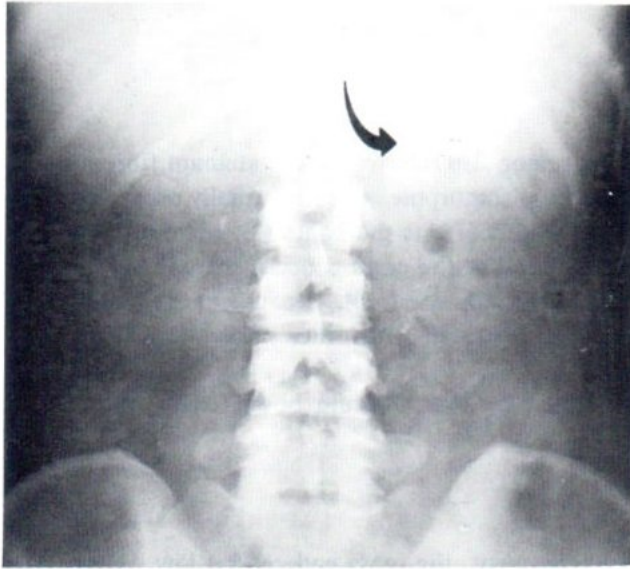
Plain film of the kidneys showed obliteration of the upper pole-left renal outline. Lateral deviation of left kidney with loss of medial outline of upper and middle pole.
